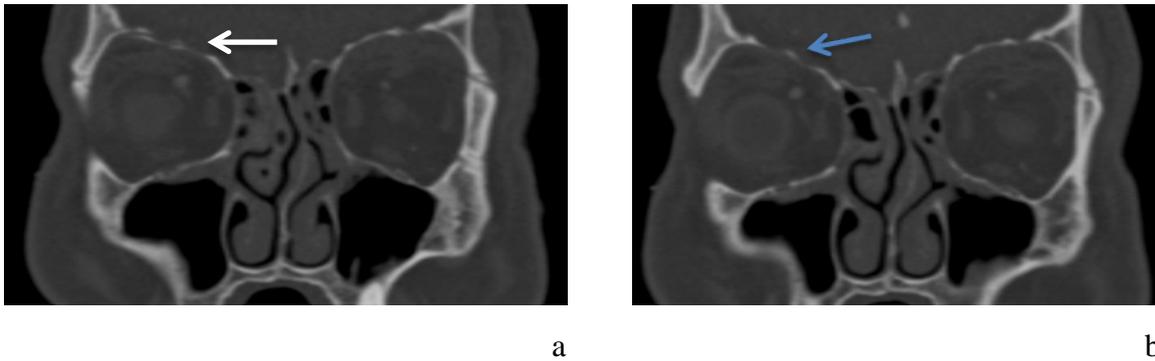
(a/b): Roof fracture, right eye (52-year-old male with elevated IOP without further restraints). CT, coronal section (a): Fracture line of the right orbital frontal bone (white arrow) and (b) fracture line of the lesser wing of the sphenoid (blue arrow).
